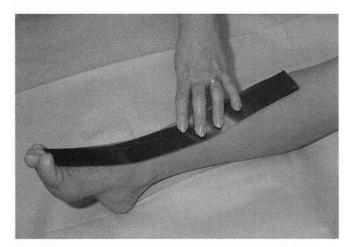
Placement of protective x-ray strips on the anterior foot and ankle.
